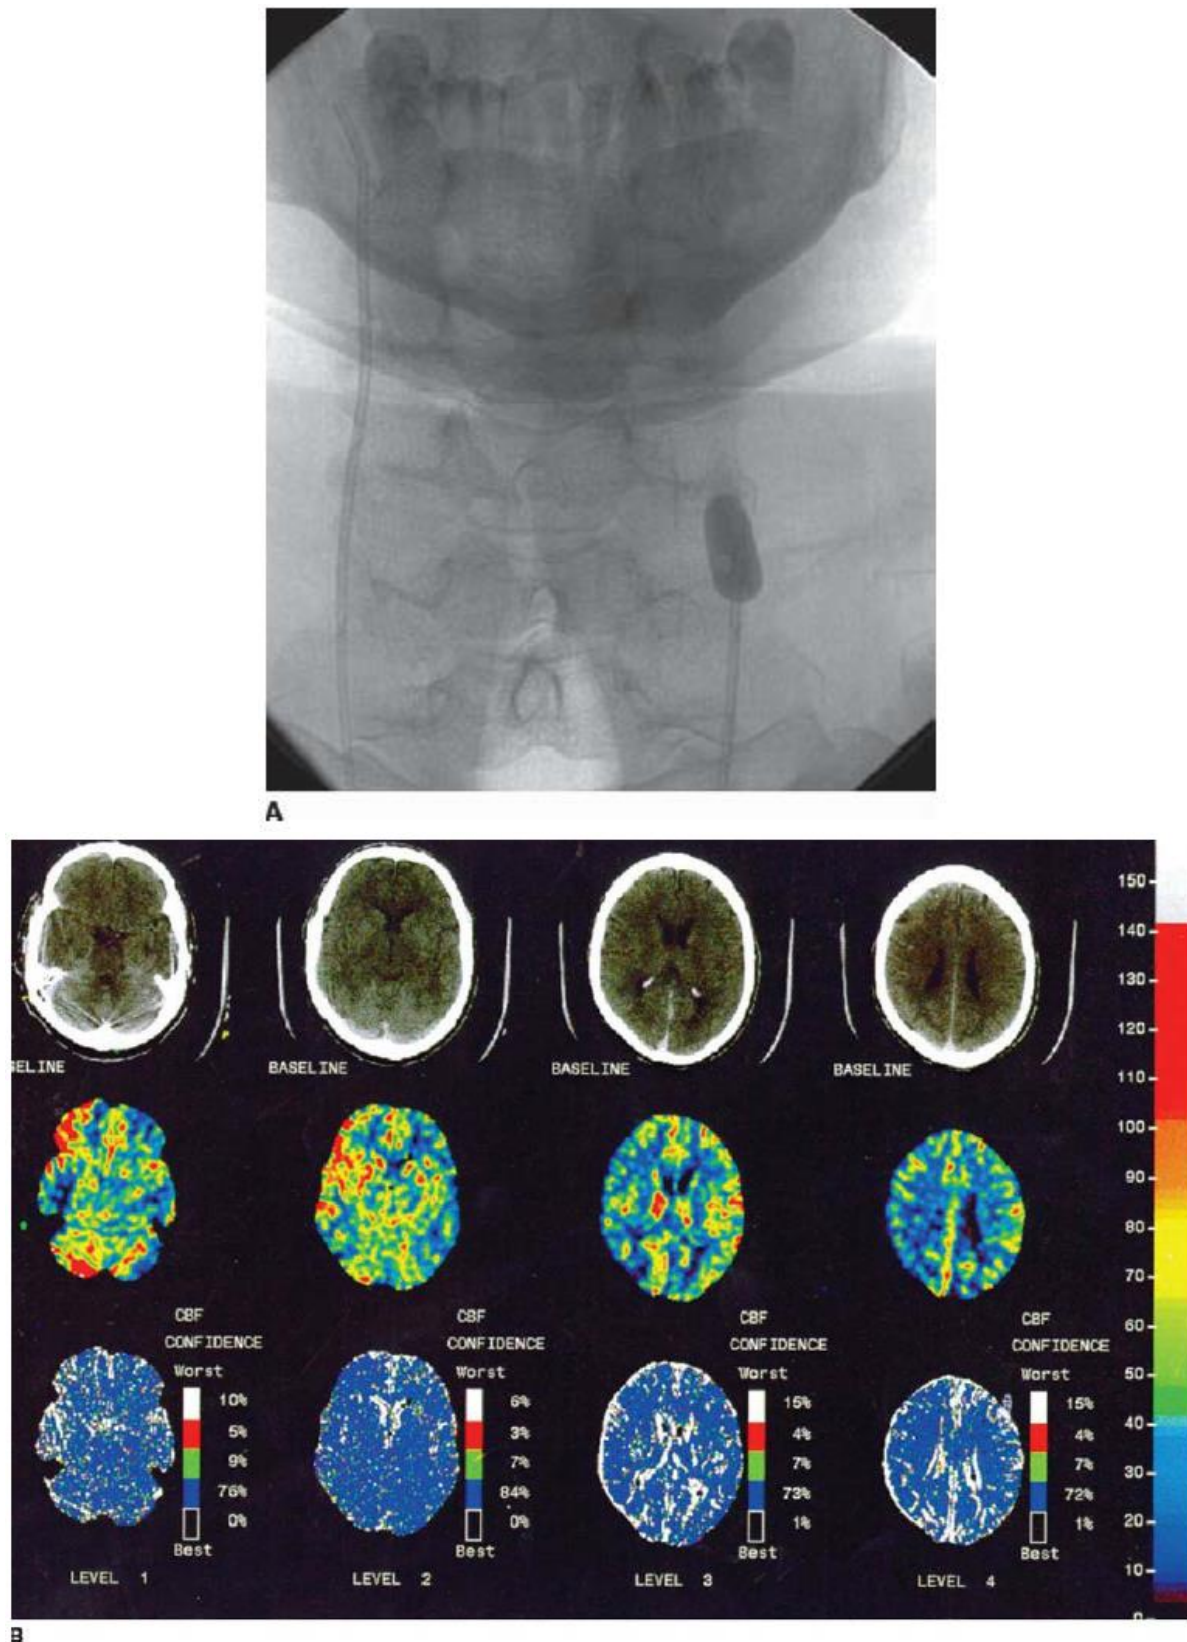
Balloon occlusion testing. A: Frontal angiographic image shows the inflated radiopaque balloon in the proximal left internal carotid artery, occluding flow. B: Quantitative cerebral blood flow images created by inhaling xenon gas during dynamic CT. The color images reveal reduced flow (blue instead of red) in the left MCA distribution.
